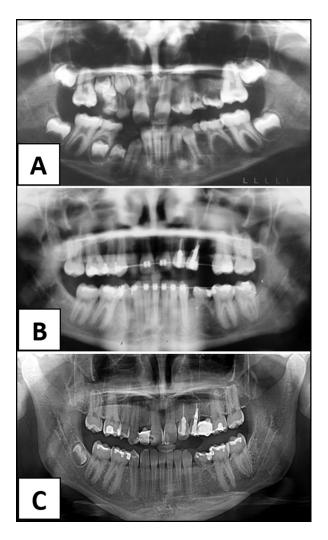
Panoramic radiographs: A, 2 years before tooth transplantation (June 2007); B, before the end of treatment; C, 18 month after orthodontic treatment (November 2015).
